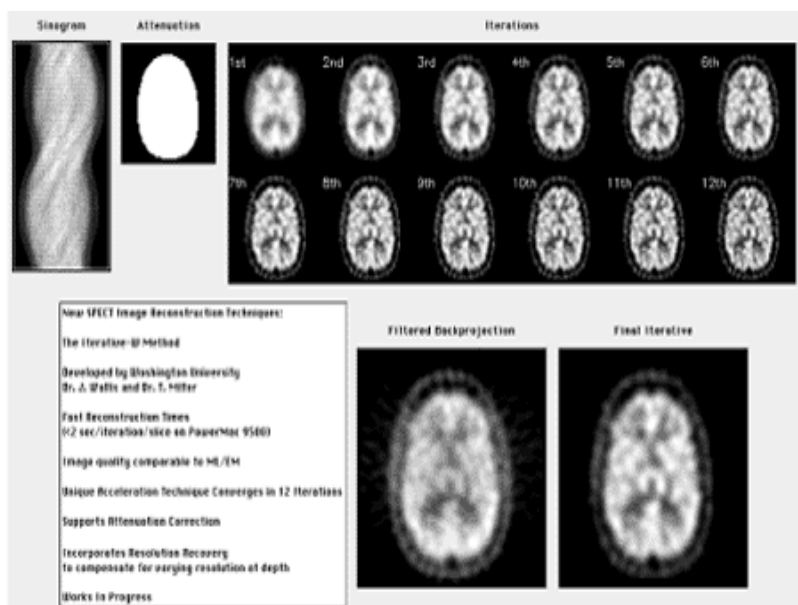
Reconstruction algorithms for SPECT. Bottom left: filtered back projection, bottom right: iterative reconstruction. (Siemens ICON software).
